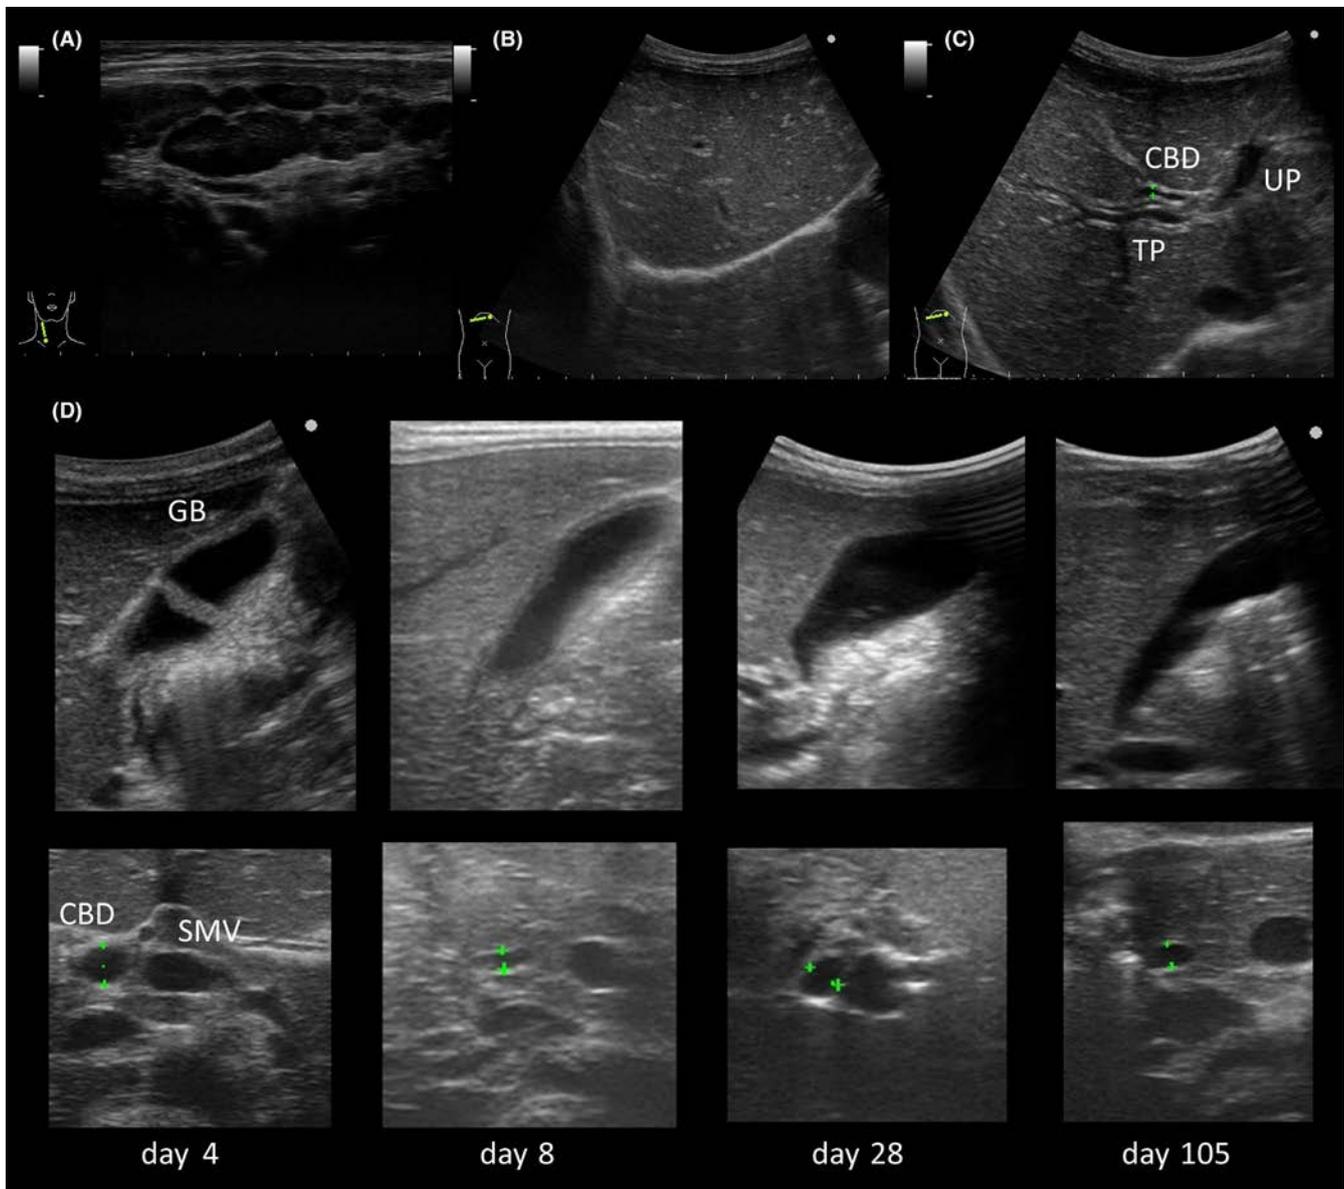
Neck and abdominal ultrasound and shift of maximum diameter of the common bile duct, performed on day 4. Neck ultrasound showed multiple hypoechoic-enlarged nodes which resembled a cluster of grapes (A). Abdominal ultrasound showed increased periportal echogenicity throughout the liver parenchyma (B), dilatation of common bile duct (C, D) and thickening of gallbladder wall (D). The maximum diameter of the common bile duct shifted as follows: day 4: 6.6 mm, day 8: 3.1 mm, day 28: 4.3 mm, day 63: 4.0 mm, day 105: 3.3 mm, and day 182: 2.8 mm (4-year-old standard value is 2.3 mm, upper limit is 3.7 mm).⁹ All tests were performed in a fasting state. Thickening of the gallbladder wall remained on day 8, but it improved after day 28. Abbreviations: CBD, common bile duct; GB, gallbladder; SMV, superior mesenteric vein; TP, transverse portion of the portal vein; UP, umbilical portion of the portal vein
